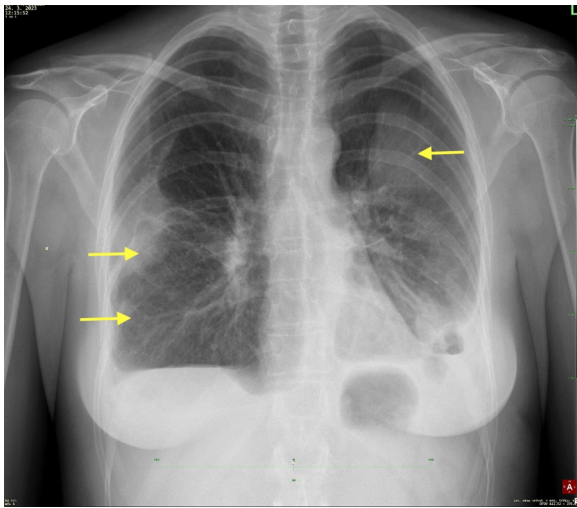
Pre-dismantling chest radiographs showing improved transparency of both lung wings with persistent opacities in the lower and middle lung field on the right and in the middle lung field on the left (arrows)
